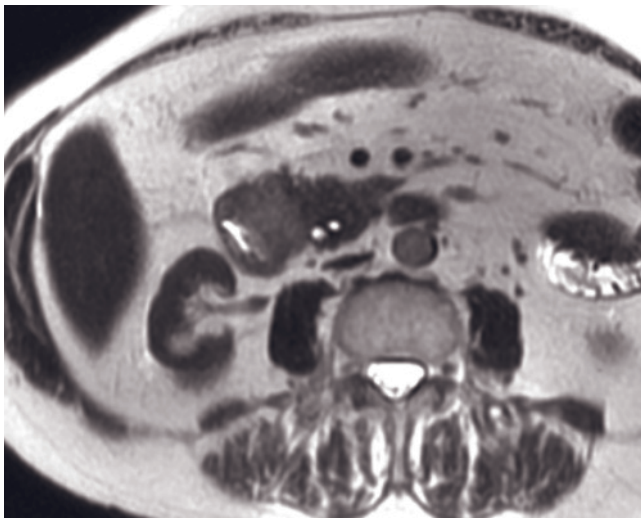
1.5T versus 3.0T. Axial single-shot T2-weighted echo-train spin-echo (a) and fat-suppressed diffusion-weighted single-shot echo planar imaging (b) sequences at 1.5T (acquired with 4-channel torso phased-array coil and parallel imaging acceleration factor of 2 for echo planar imaging) show a small cyst in the right liver. Axial single-shot T2-weighted echo-train spin-echo (c) and fat-suppressed diffusion-weighted single-shot echo planar imaging (d) sequences at 3T (acquired with 8-channel torso phased-array coil and parallel imaging acceleration factor of 2 for both sequences) show a slightly better image quality with improved SNR and reduced image blurring.
